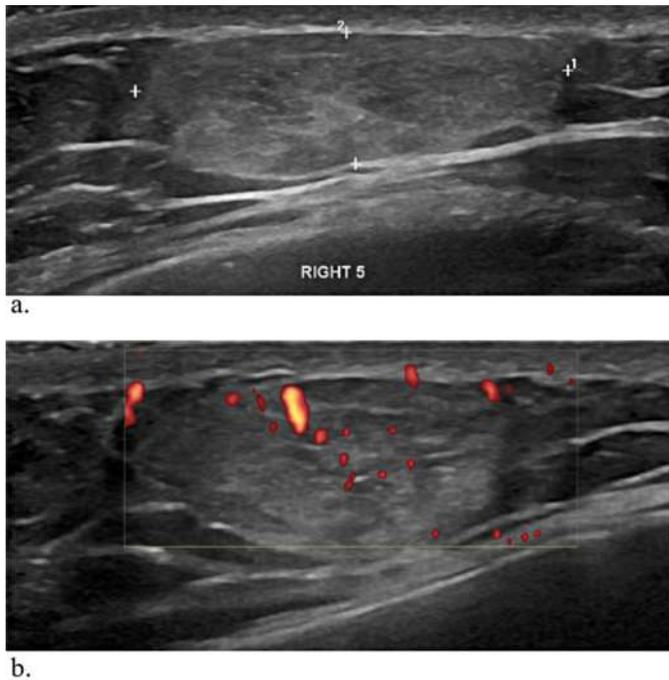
A) US image showing a well-circumscribed, homogeneous, echogenic mass; B) minimal vascularity in doppler US examination.
